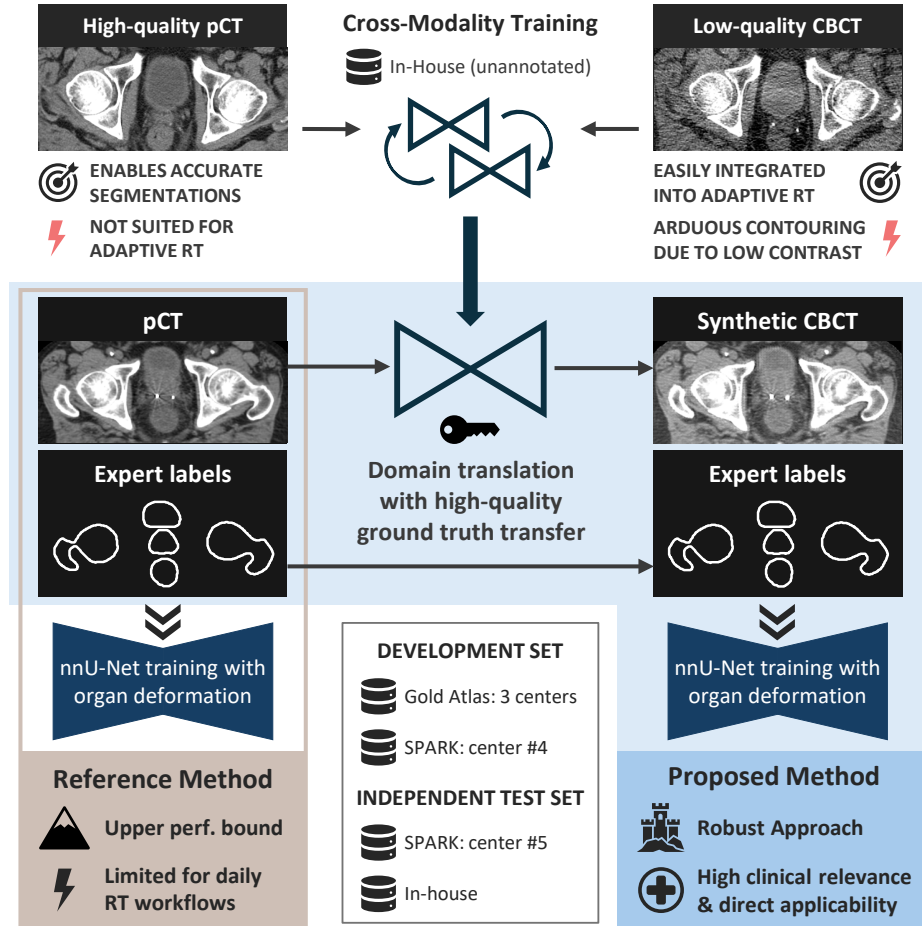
Our proposed framework addressing annotation scarcity on low-quality CBCT images. By combining generative modeling with robust augmentation strategies, our method facilitates clinically viable AI-driven segmentation for adaptive radiotherapy.
